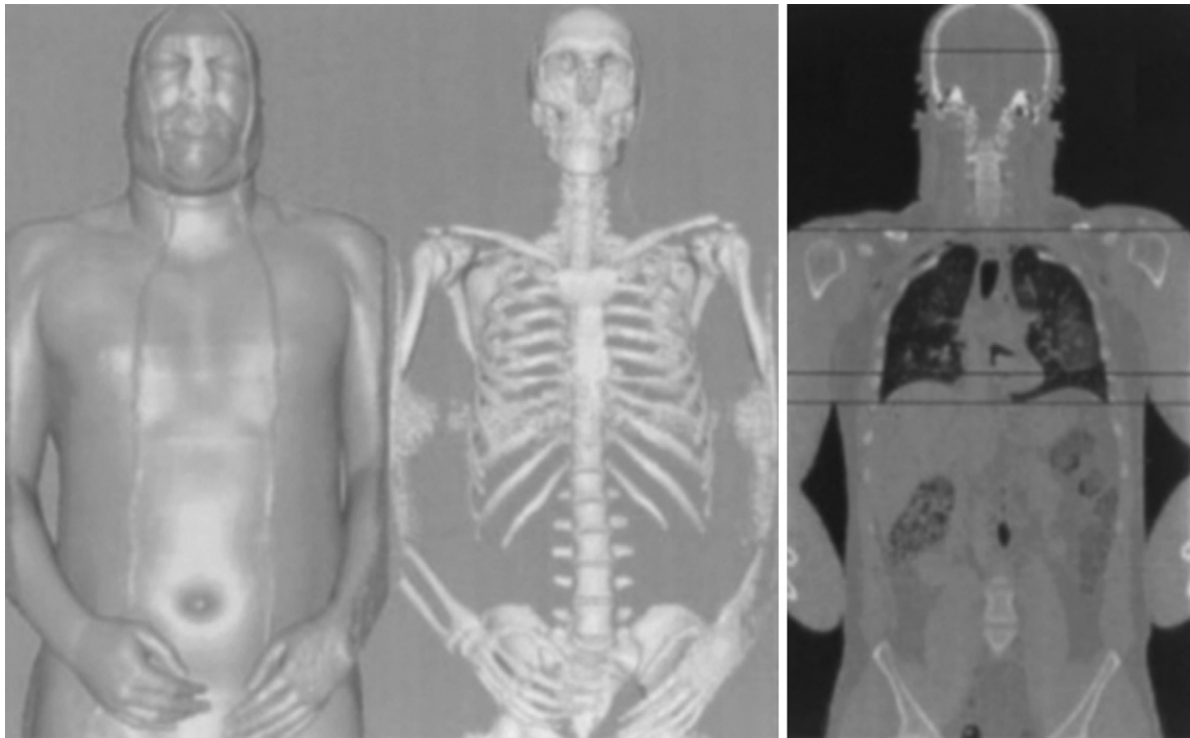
Visible Human Project. Reconstruction of a 3D model based on MRI and CT data. (Courtesy the National Library of Medicine Dataset.)
